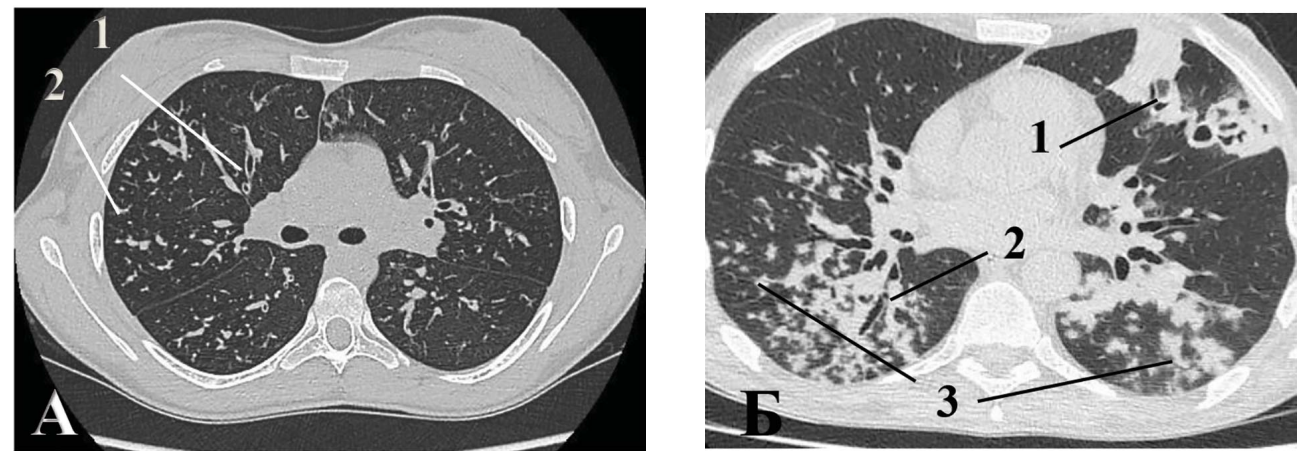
CT picture of chronic infectious bronchiolitis
